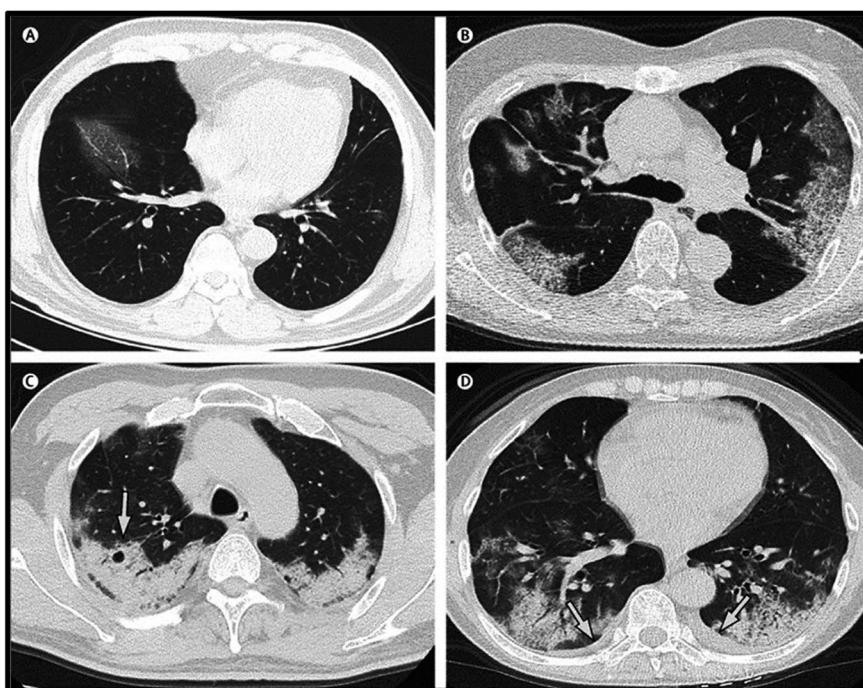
CT scans (transverse thin-section) in SARS COV-19 patients: (A) a 56 year-old man at 3rd day after symptom onset; (B) a 74 year-old woman at 10th day after symptom onset; (C) a 61 year-old woman at 20th day after symptom onset; (D) 63-year-old woman at 17th day after symptom onset. The figure has been reproduced from ref. 111 with permission from Elsevier, copyright 2020.
